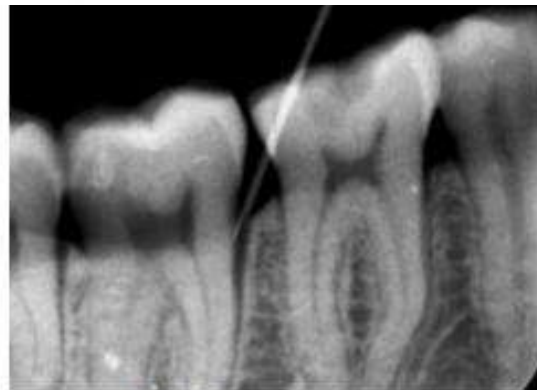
Radiograph showing the needle position for the periodontal ligament anesthetic injection technique.
